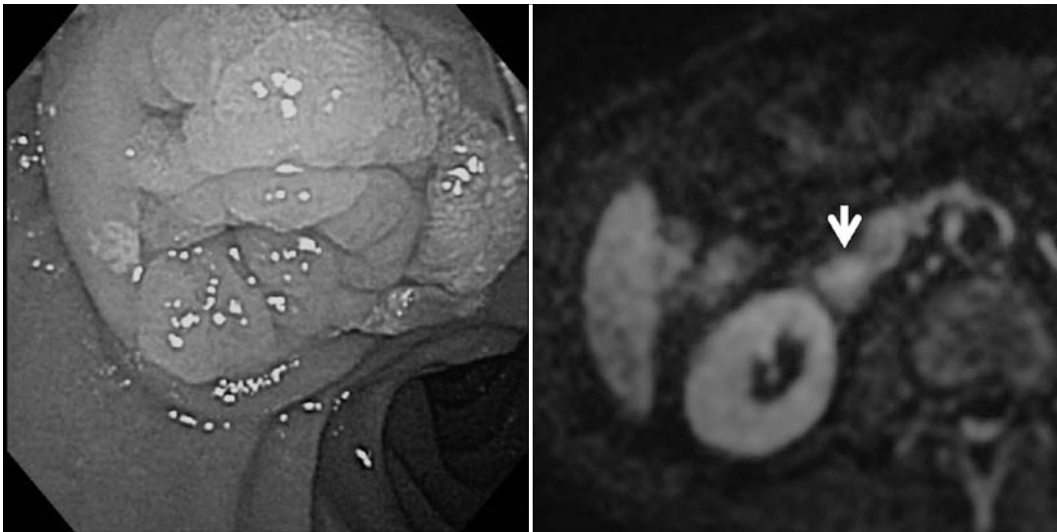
Endoscopy and diffusion-weighted magnetic resonance imaging of Case 8 (cancer in adenoma). The endoscopy showed an elevated lesion with granular surface in the ampulla of Vater (left). Diffusion-weighted magnetic resonance imaging revealed the tumor, which was markedly hyperintense relative to the adjacent duodenal wall (white arrow).
